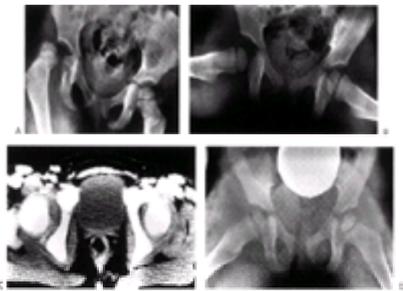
Traumatic hip dislocation. A: Anteroposterior projection of a 3-year, 6-month-old child with a low-energy injury producing a posterior hip dislocation. B: An anteroposterior view of the pelvis after closed reduction of the hip, taken in an emergency department. Clinically, a stable reduction was obtained, but there is significant joint space widening, suggesting an intraarticular obstruction. C: The computed tomography scan confirms incomplete reduction. There is some radiodense material in the posterior acetabulum. D: Posterior open reduction of the hip was performed, and the interposed soft tissue was removed. There was no osteochondral fracture. An anteroposterior radiograph of the pelvis confirms the concentric symmetric reduction of the hip. A spica cast was applied for 4 weeks.
